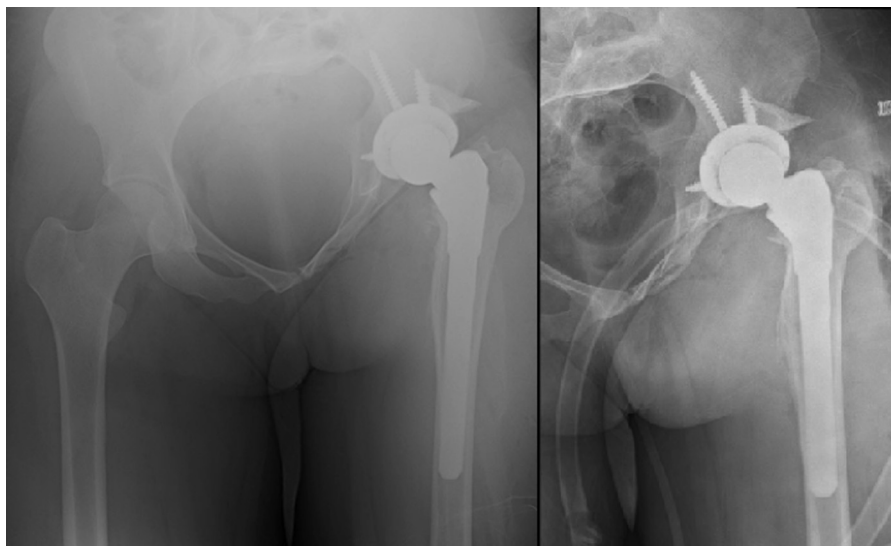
Anteroposterior pelvis and anteroposterior left hip radiographs taken immediately postoperatively demonstrate total hip arthroplasty with an appropriately positioned acetabular component, screws, and femoral component. A residual leg length discrepancy of 5 cm is noted on the anteroposterior pelvis radiograph.
